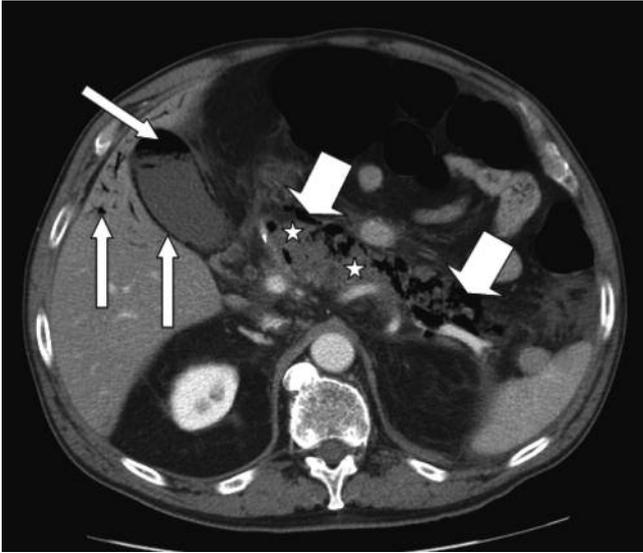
Enhanced CT, one day later: emphysematous (large arrows), necrotizing (stars) pancreatitis, together with gas (long arrows) in the vesicular lumen and wall, and in some portal veins (Balthazar grade E, severity index 10).
